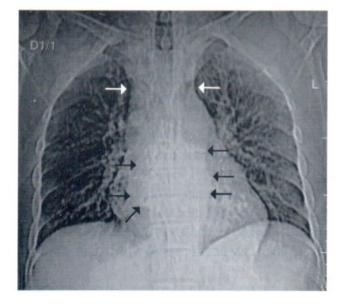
Chest roentgenograph demonstrates coarse bony trabeculations and paravertebral soft tissue shadow along both sides of mid thoracic spines.
